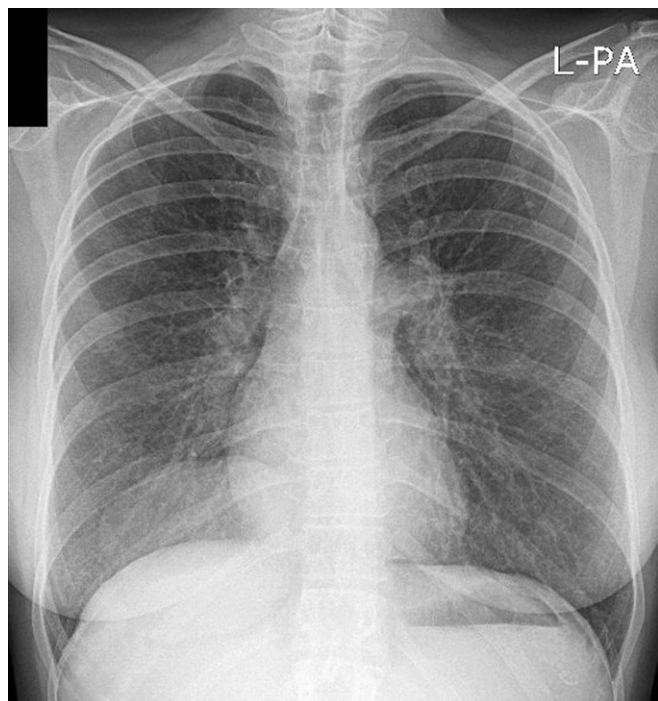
Chest X-ray shows right-sided pleural effusion with sharp margin above the diaphragm. In the right lower lobe there are opacities caused by compressed parenchyma. Hilum is slightly enlarged due to dilated pulmonary artery.
